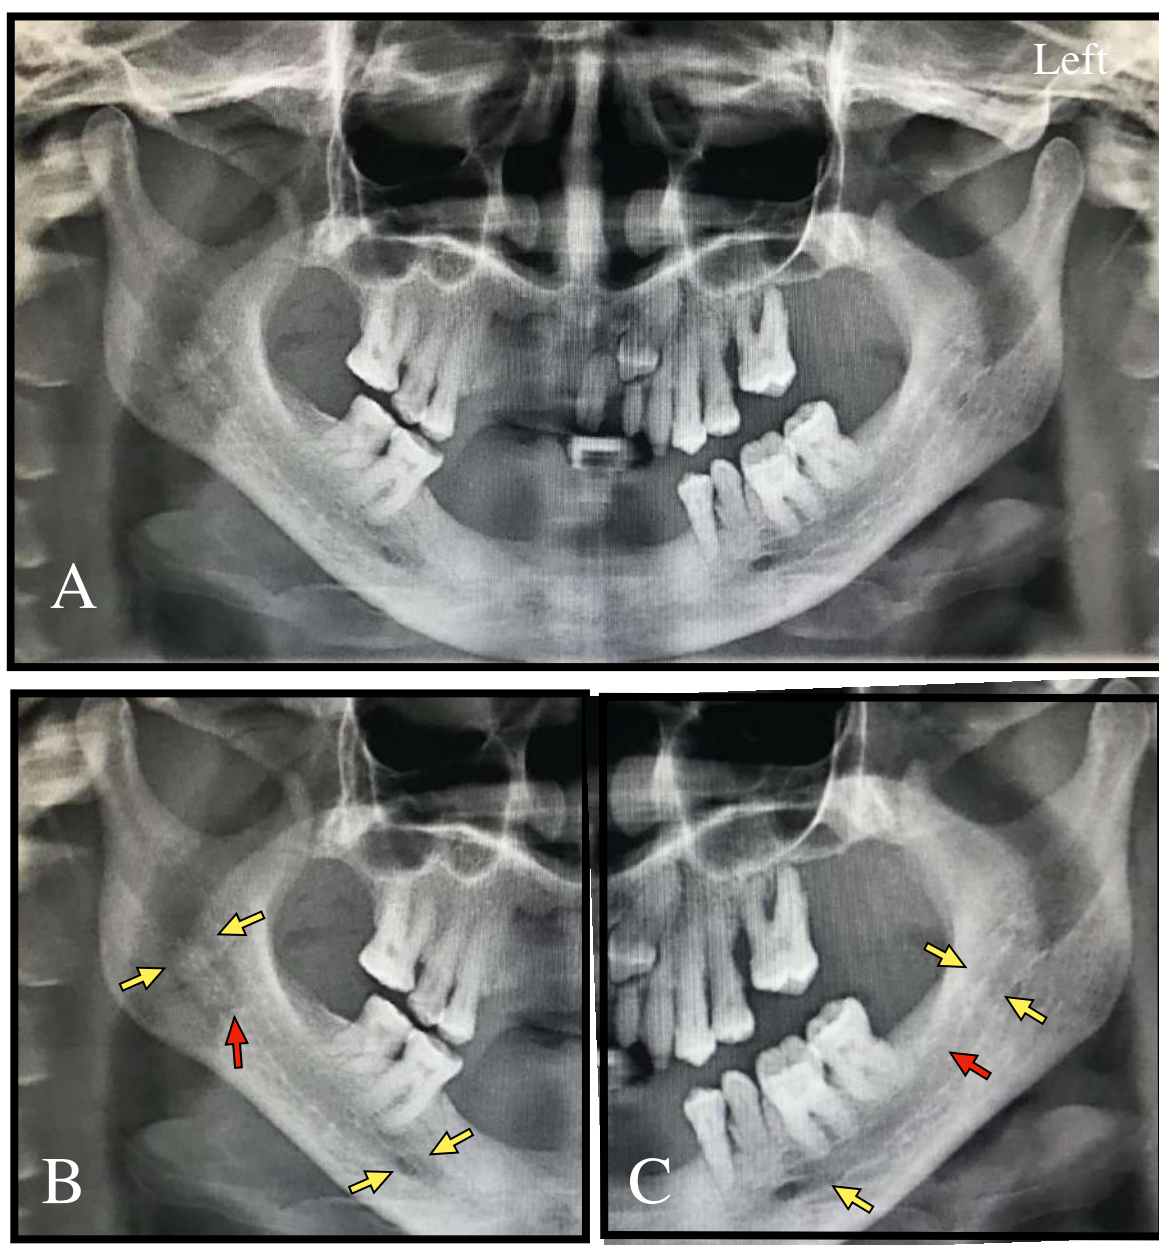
Panoramic Radiograph , 2A - OPG reveals Bifid Mandibular Canals (BMCs) bilaterally, multiple partially edentulous space, impacted 23, retained deciduous 62,63, Generalised chronic periodontitis, 2B - yellow arrow shows right side BMC extending till mental foramen with branching at retromolar region shown by red arrow, 2C- yellow arrow shows left side BMC which extends till the third molar region and joins to form a single canal which is shown by red arrow.
